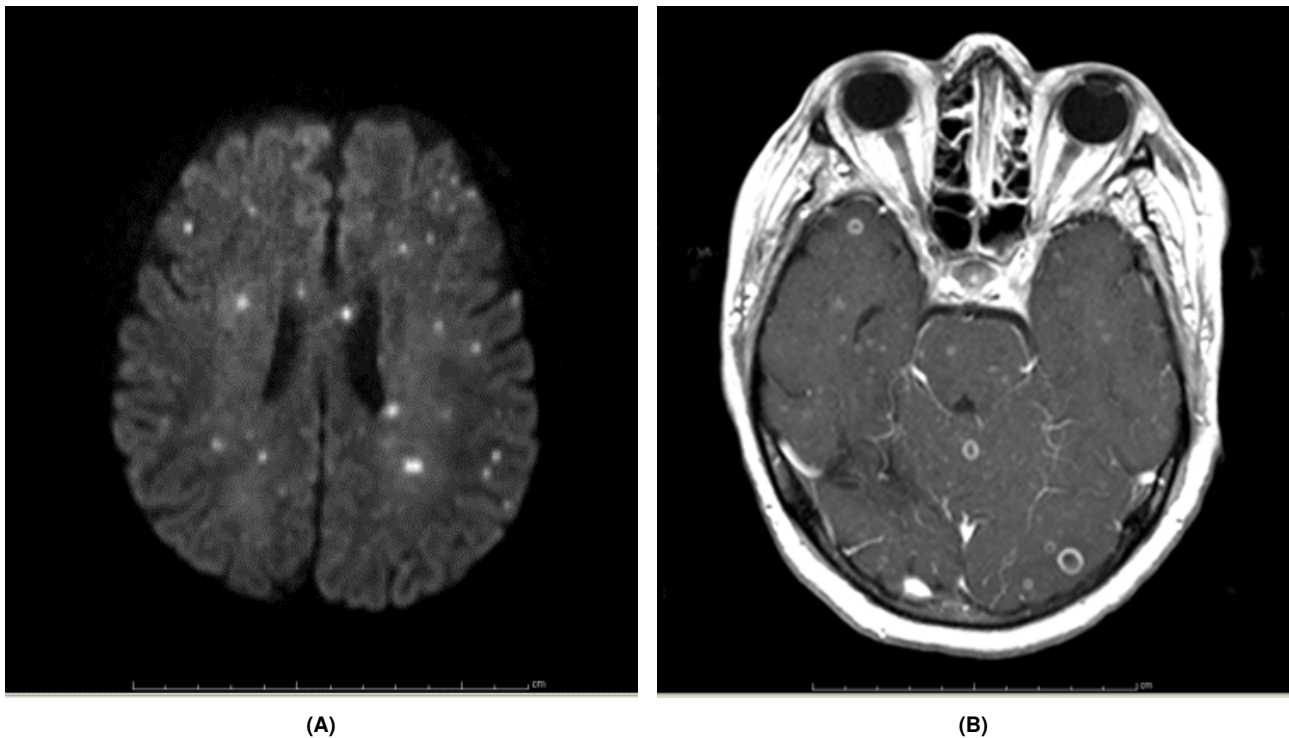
MRI of the brain on hospital day No. 4 showing too numerous to count post-contrast, ring-enhancing lesions with axial diffusion weighted imaging (Panel A), and T1 with contrast enhancement (Panel B) throughout the supratentorial and infratentorial brain.
